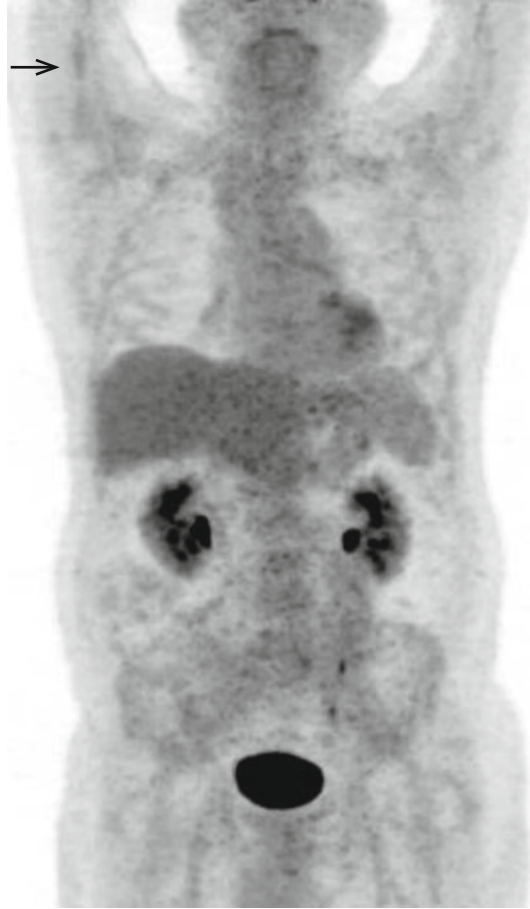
MIP-PET and fused PET/CT – interim PET: No abnormal FDG uptake is shown in the neck. A small focus with mildly increased metabolic activity is observed in the shaft of the right humerus (*arrow*)
